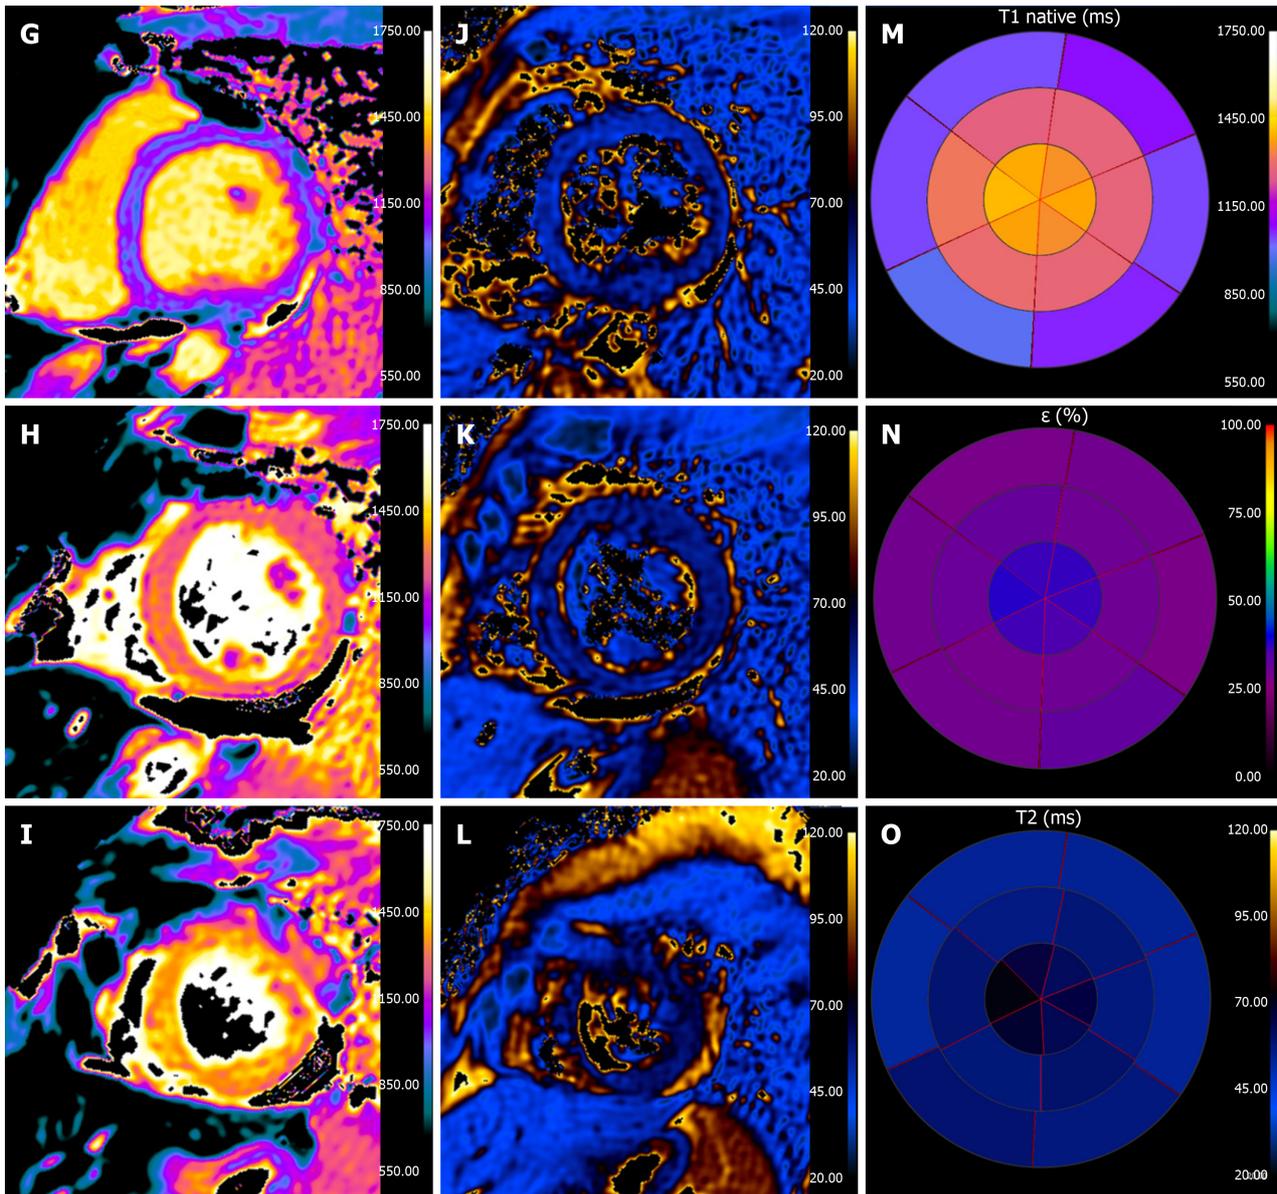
Thirty eight years old female presented with acute chest pain, increased troponin values and negative coronary angiogram. A and B: Diastolic and systolic 4-chamber cine-SSFP images: there is a minimum “apical ballooning” appearance with a relative left ventricle apical akinesia with preserved function of the remaining segments, which causes the typical “apical ballooning” appearance; C and D: T2-weighted short-tau inversion recovery images with evidence of myocardial edema in apical segments (arrows); E and F: Ate gadolinium enhancement images without presence of areas of increased signal intensity; G-I: T1-map; J-L: T2-map. M-O: T1 native, extracellular volume and T2 mapping bull’s eye, there is a marked increase in values in the apical segments (T1 mapping: 1350 ms; extracellular volume: 38%, T2 mapping: 70 ms). The cardiovascular magnetic resonance images are in keeping with Takotsubo syndrome.
